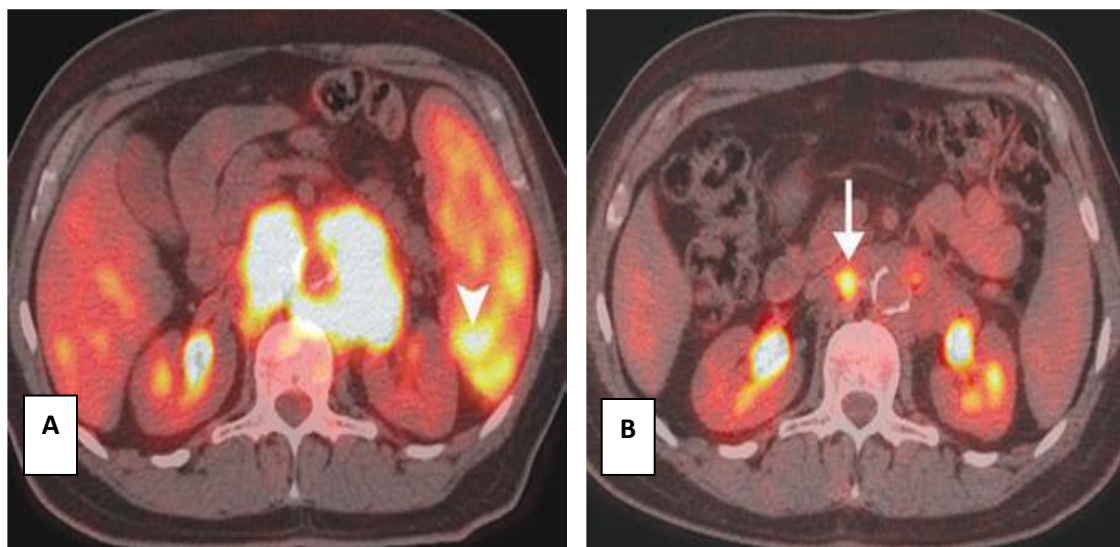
66-year-old man with stage IV diffuse large B-cell lymphoma. A, Axial fused PET/CT image from baseline PET/CT examination shows 18F-FDG-avid lymphadenopathy in paraaortic regions in addition to splenic involvement (arrowhead). B, three cycles of systemic chemotherapy resulted in marked anatomic response with almost complete interval resolution of lymphadenopathy on CT images. Fused PET/CT image, however, shows persistent abnormal 18F-FDG uptake within small residual lymph node in retroperitoneum (arrow). Finding is consistent with residual viable lymphoma. (7)
